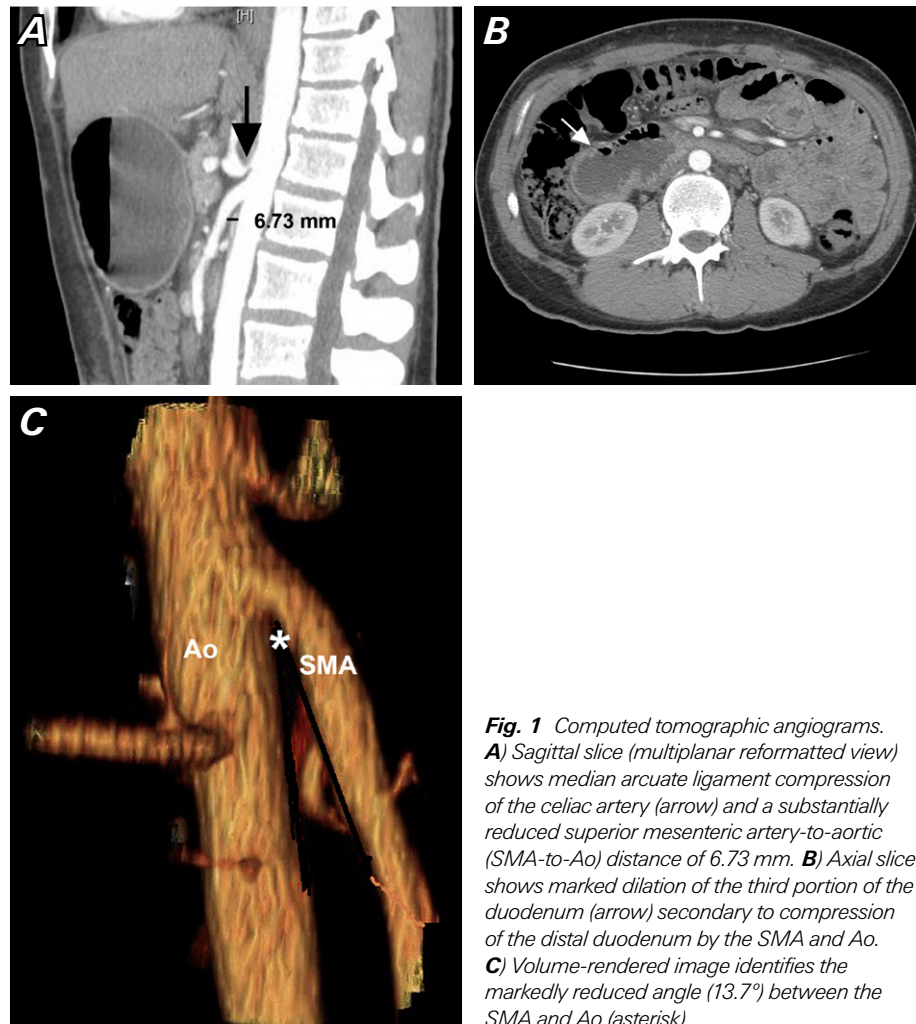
Computed tomographic angiograms. A) Sagittal slice (multiplanar reformatted view) shows median arcuate ligament compression of the celiac artery (arrow) and a substantially reduced superior mesenteric artery-to-aortic (SMA-to-Ao) distance of 6.73 mm. B) Axial slice shows marked dilation of the third portion of the duodenum (arrow) secondary to compression of the distal duodenum by the SMA and Ao. C) Volume-rendered image identifies the markedly reduced angle (13.7°) between the SMA and Ao (asterisk).
